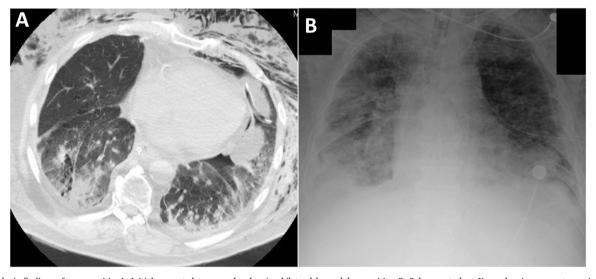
Radiologic findings of pneumonitis. A. Initial computed tomography showing bilateral lower lobe opacities. B. Subsequent chest X-ray showing an acute respiratory distress syndrome (ARDS).
